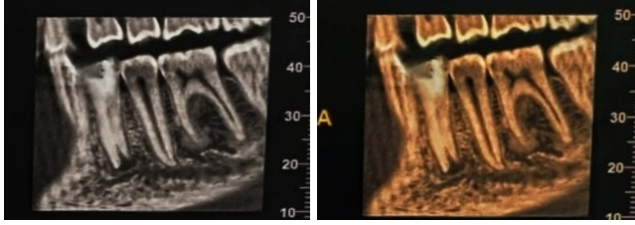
Preoperative intraoral radiograph of mandibular right 1st premolar showing two roots and periapical radiolucency (CBCT)
